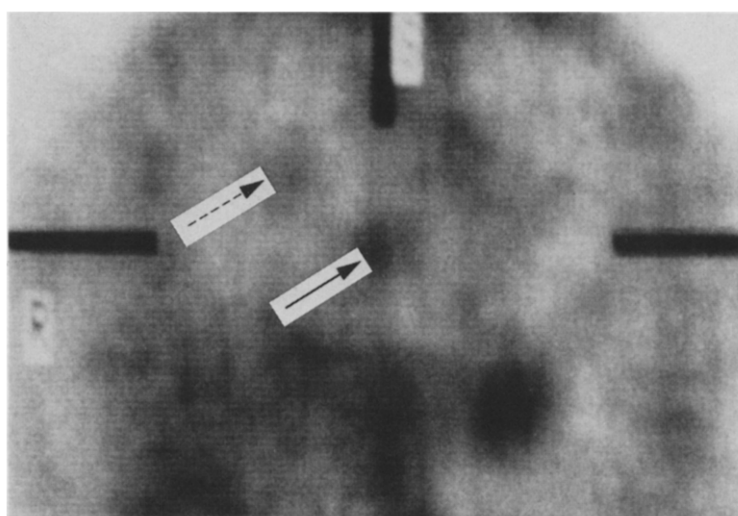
Immunoscintigraphic SPECT image of patient 5 with a known solitary metastasis in the right lung. Scan obtained 52 h after the injection of 0.8 mg ^{131}I -labelled TP-1F $(\text{ab}')_2$. Note blood pool activity in the liver, heart and the accumulation of free iodide in the stomach. → Known lesion. - - - Unknown lesion.
